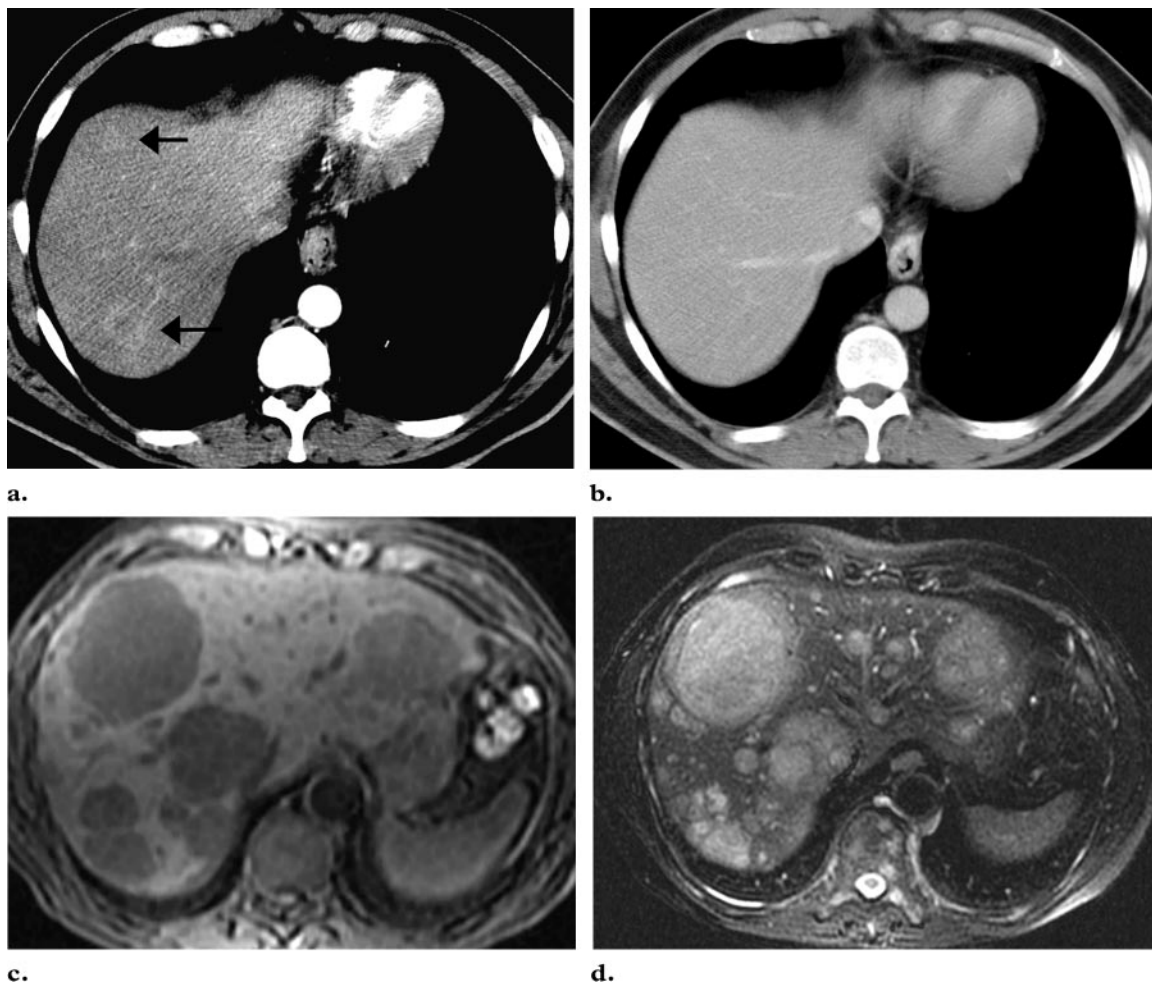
Hepatic metastases of carcinoid disease. (a) Contrast-enhanced arterial phase CT image shows avidly enhancing foci in the liver (arrows), features indicative of hepatic metastases in a patient with a gastric carcinoid tumor. (b) Contrast-enhanced portal phase CT image at the same level as a shows no foci of enhancement. (c, d) Axial T1-weighted MR image (c) and T2-weighted MR image (d) show regions of low T1-weighted signal intensity and high T2-weighted signal intensity, respectively, findings typical of carcinoid liver metastases.
